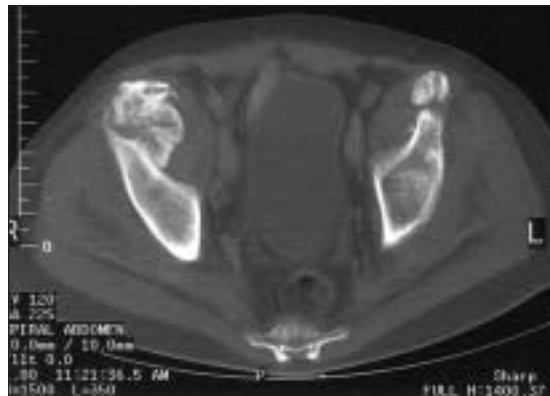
Computed tomography of the pelvis demonstrating ossification in the iliopsoas muscles bilaterally.
